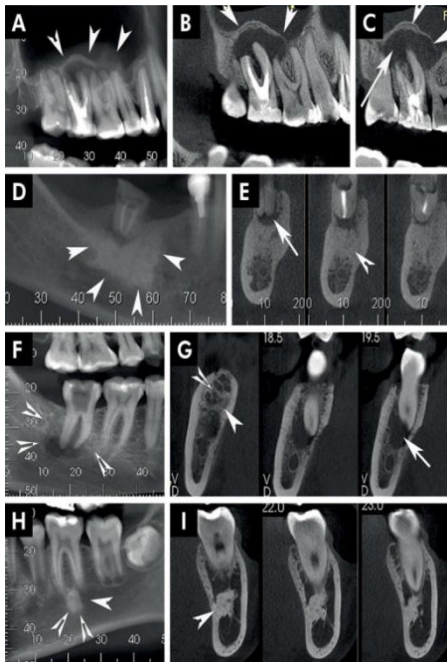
Condensing osteitis (CO): CBCT exposed a diffuse radiopaque lesion in the apex of mandibular molar (arrow) (D), adjacent to inflammatory periapical lesion (arrow) (E).
